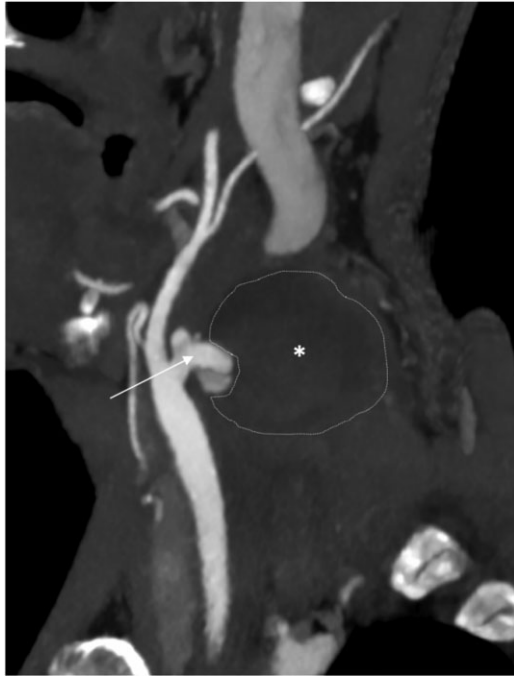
Preoperative contrast computed tomography: pseudoaneurysm × (38 × 31 mm) with origin of the right internal proximal artery with 6 mm neck (arrow). Internal carotid artery occluded.
